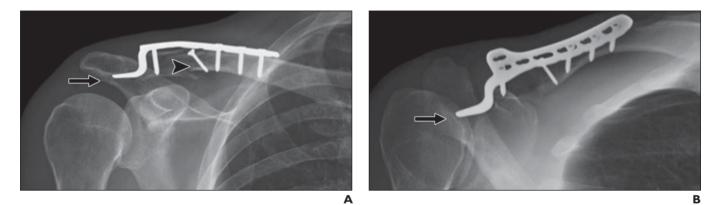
Use of blade hook clavicle plate to treat distal third shaft right clavicle fracture in 58-year-old woman. A and B, Anteroposterior (A) and anteroposterior oblique (B) radiographs of distal third shaft right clavicle fracture show blade hook clavicle plate. Hook is within 1–2 mm of undersurface of acromion (*arrow*) and is posterior to acromioclavicular joint, which is normal location. Interfragmentary screw (*arrowhead*, A) is also present.
